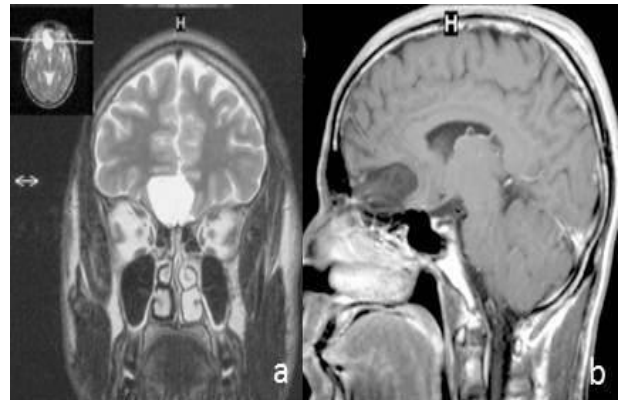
MRI brain of patient 2, (a) T-2 weighted MRI (coronal section) revealing a midline fronto-basal mass producing homogenous hyperintense signals without any perifocal edema, (b) post-gadolinium T-1 weighted MRI (sagittal section) showing no post-contrast enhancement. The features suggest the diagnosis of a fronto-basal epidermoid cyst.
